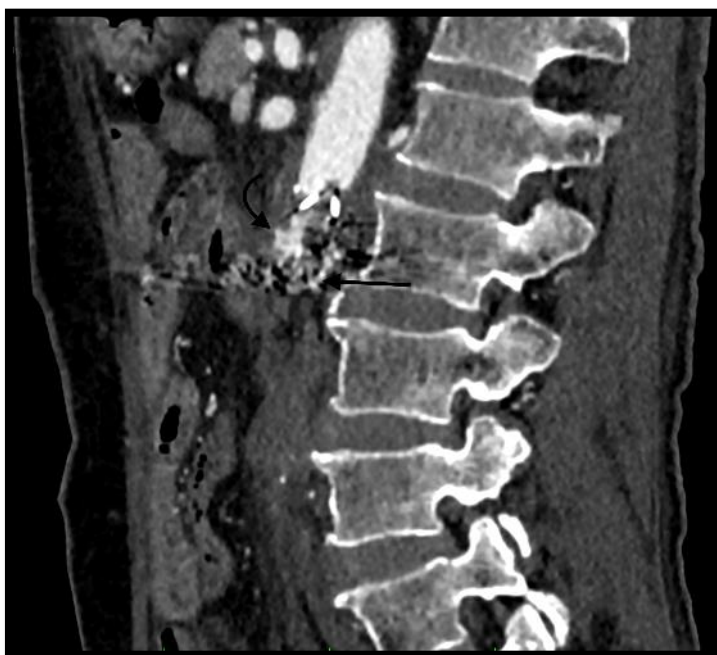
Selected sagittal image of CTA Abdomen (arterial phase).
